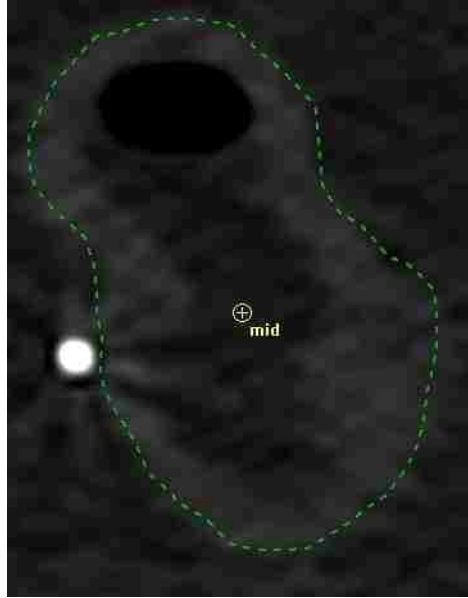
Axial CT slice of a surrogate rectum containing the centroid. This is an example of the slices used for two-dimensional CTP distances discussed in this section.
